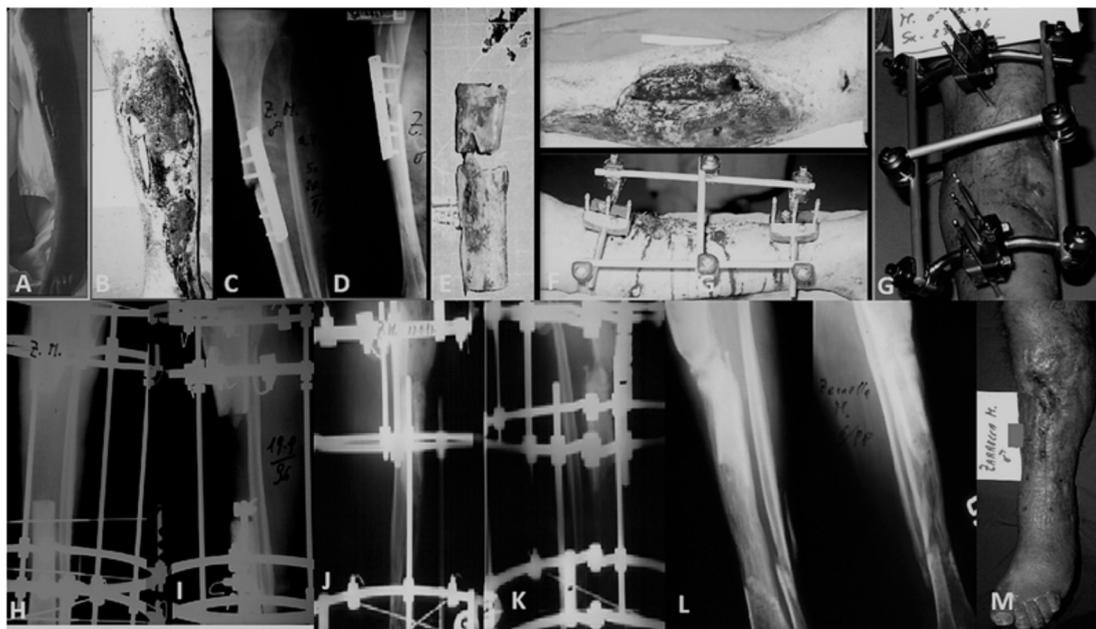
45-year-old male with surgical wound complication at 4 months after proximal tibial fracture treated with straight plate and screws, in another hospital A,B) Cutaneous defect presentation; C,D) Radiographs preoperative; E) Bone resection; F) implant of modular external fixator; G) for healing the skin; H,I) implant of Ilizarov's frame; J,K) docking point; L) good clinical and radiographic results according to ASAMI classification; M) cutaneous defect healing (Falzarano G. 2014)
